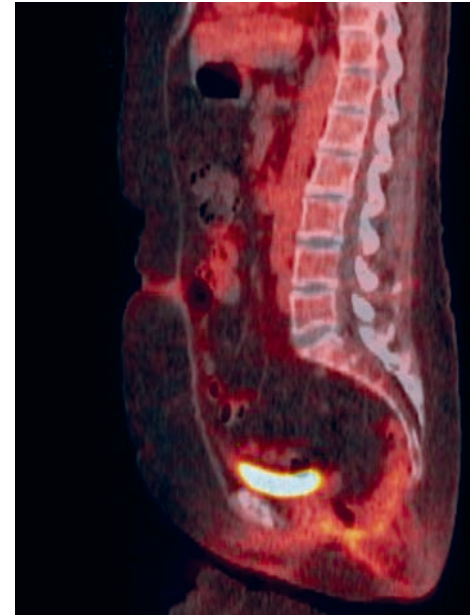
FDG PET/CT Scan shows some inferior descent of the pelvic small bowel loops.
